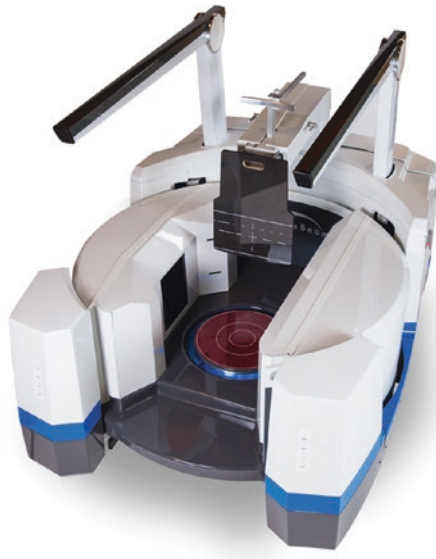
LineUp® (CurveBeam, Philadelphia, PA, USA). Physical dimensions of this device are as follows: length, 48"; width, 28.5"; and height, 51.3". Weight bearing CT imaging of the knee is achieved by elevation of the gantry while the patient is in physiological bipedal stance. Non-weight bearing CT imaging is also available but requires the patient to be seated in a chair. The first study using this device included both technical details and clinical applications [13]. In comparison with MRI and X-rays, weight bearing CT imaging was more sensitive and accurate to detect knee osteoarthritis. Full technical details can be found on the website: <https://www.curvebeam.com/products/lineup/>
